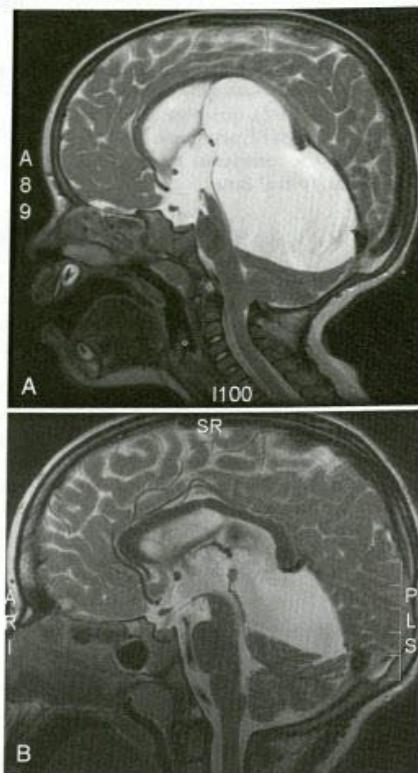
Magnetic resonance images of a quadrigeminal cistern arachnoid cyst with obstructive hydrocephalus in an 18-month-old girl with progressive head enlargement before (A) and 5 years after (B) endoscopic fenestration into the lateral ventricle.
